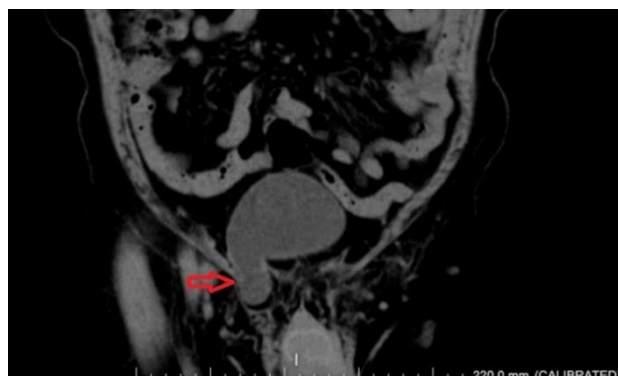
Coronal CT demonstrating a right-sided inguinal bladder herniation (red arrow) extending into the inguinal canal and prominent prostatic hypertrophy inferior to the bladder
